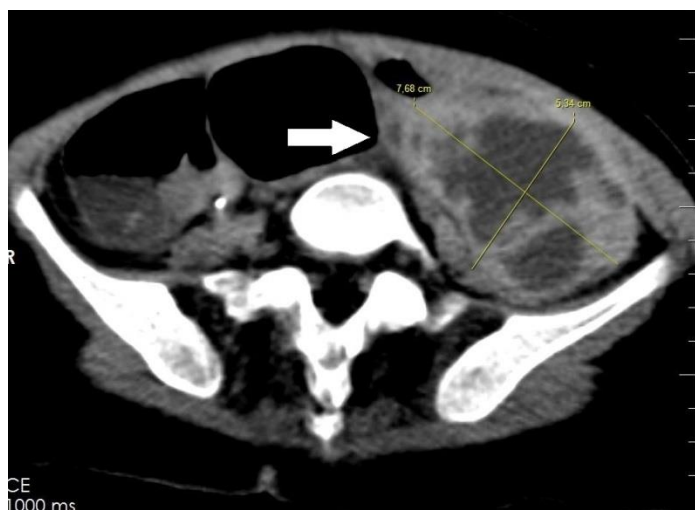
Intravenous contrast-enhanced abdominal computed tomography showing a cystic lesion with the dimensions of ~7x6x5 cm filled with a dense material, including multiple septations within in the left ovarian region (arrow).
